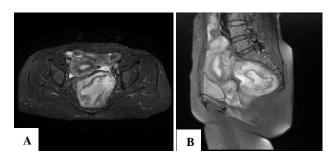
MRI image of the lesion (A) sagittal section of the pelvis showing the lesion behind the uterus; (B) coronal section depicting the same.
